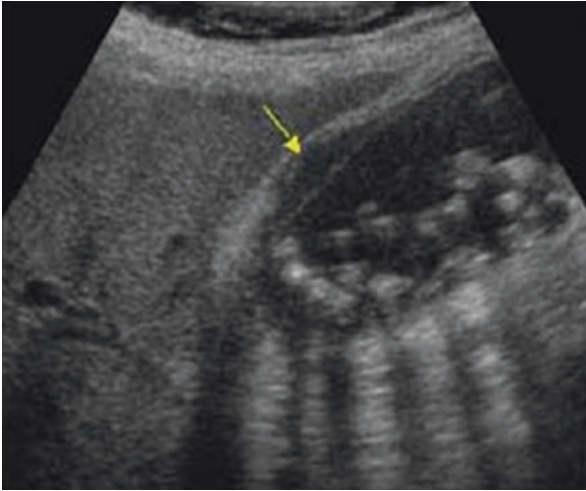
Ultrasound of gallbladder demonstrating multiple stones with acoustic shadowing, thickened gallbladder wall, and *arrow* pointing to pericholecystic fluid indicative of acute cholecystitis
